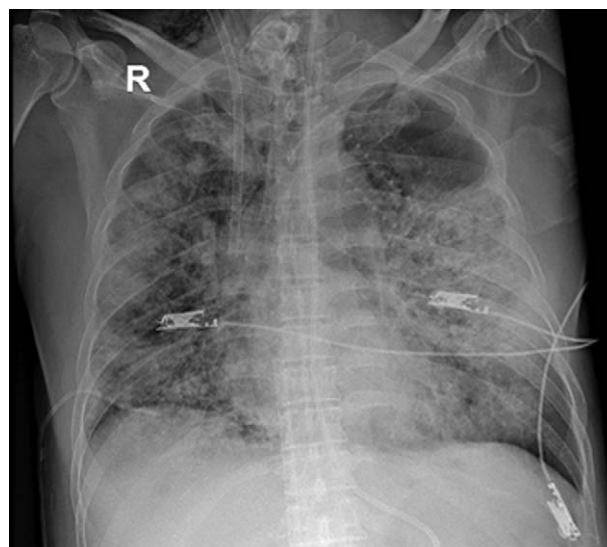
Chest X-ray revealing an improvement of infiltrates in both lungs.
